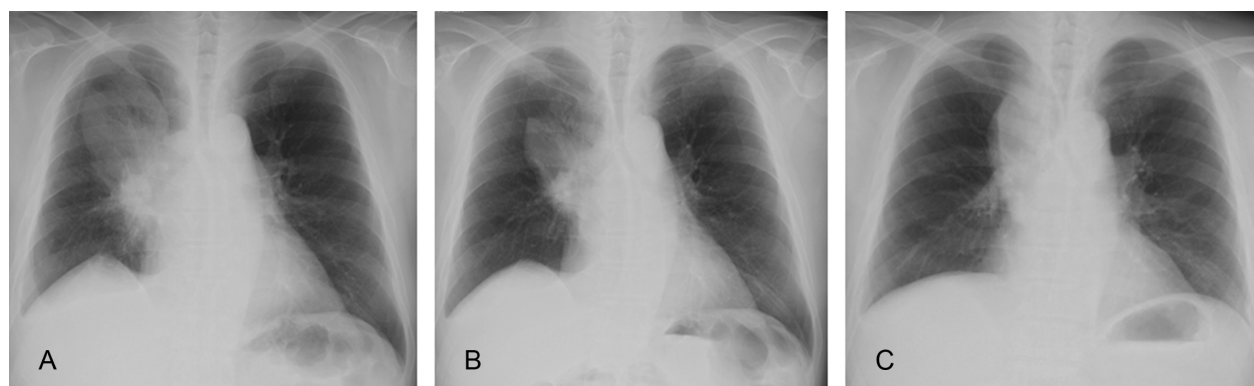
Chest X-ray showed upper lung field infiltration at diagnosis (A). After one cycle of carboplatin and etoposide (B). After four cycles of carboplatin and etoposide (C).
